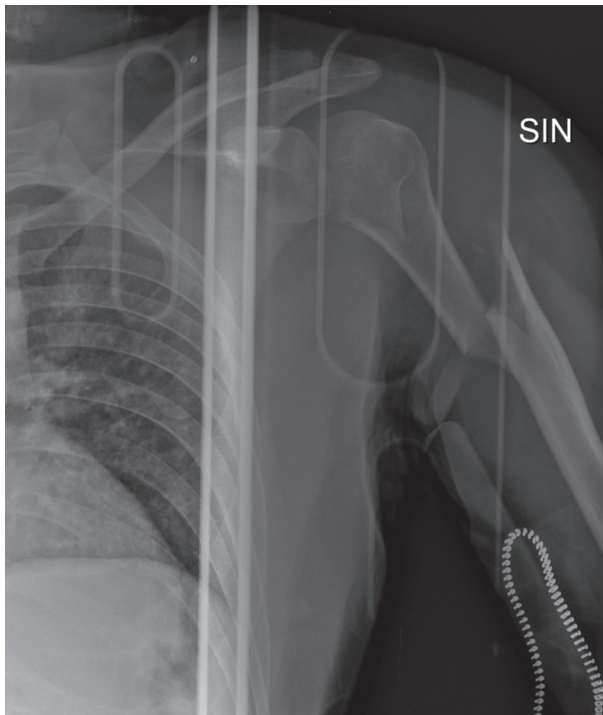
Preoperative X-ray (AP view)
